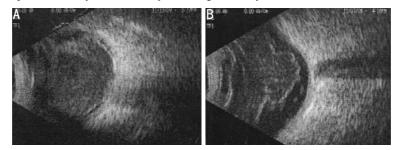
Ultrasonographic picture in the left eye of patient 1 A:Ultrasonographic picture showing vitreous was full of middle-echo spot; B: Ultrasonographic picture showing vitreous opacivies and posterior vitreous detachment
